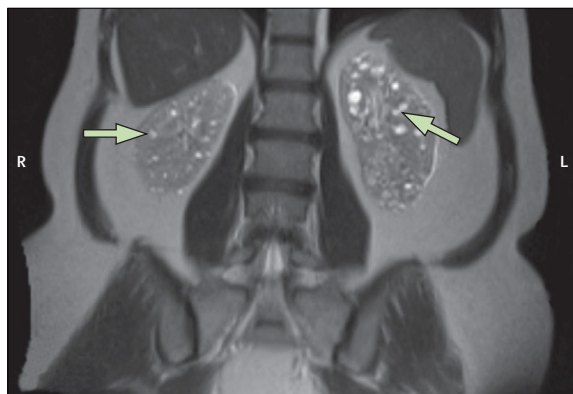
Coronal T2 MRI of abdomen
